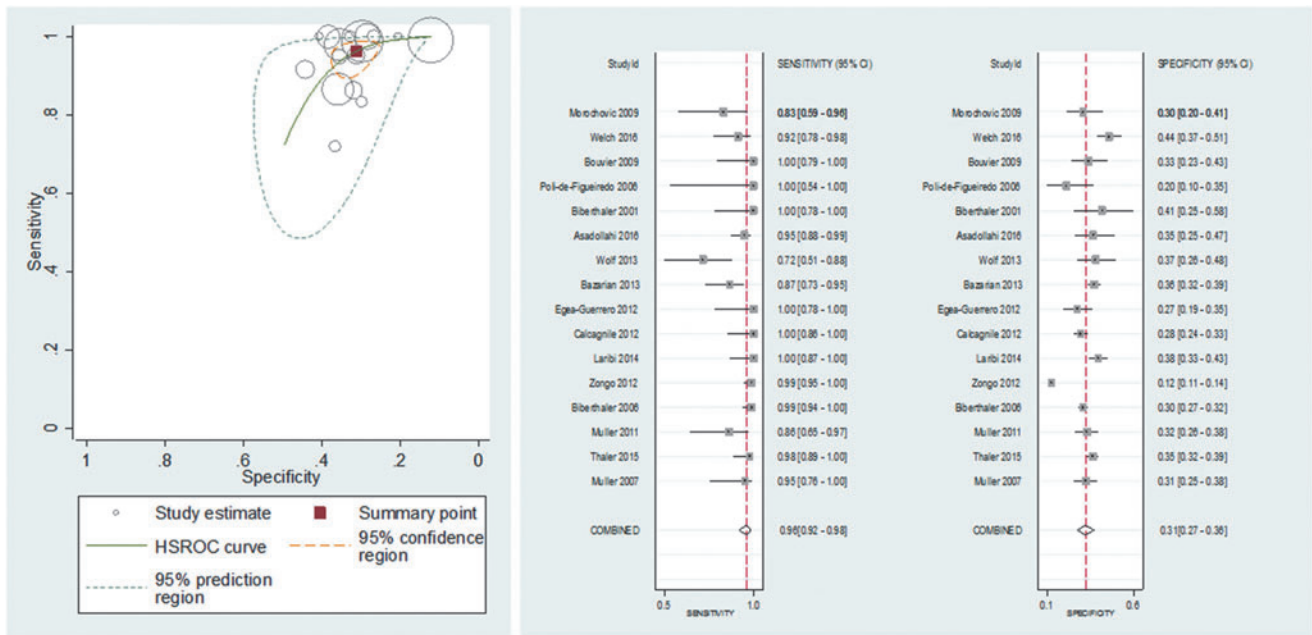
Summary receiver operating characteristics plot of sensitivity and specificity of S100 calcium binding protein B (S100B) at a 0.10–0.11 µg/L cutoff value for detecting intracranial lesions on CT. Each circle represents an individual study; size of the symbol reflects the number of patients in the studies; red solid spot in the middle is summary sensitivity and specificity; inner ellipse represents 95% confidence region, and outer ellipse represents 95% prediction region.
